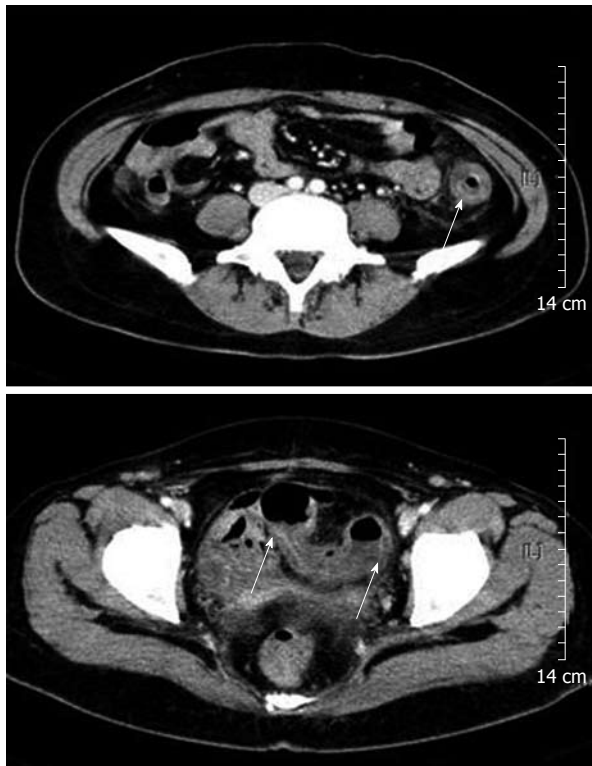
Abdominal computed tomography. A: Circumferentially layered wall thickening and pericolic fat infiltration at the descending colon (arrow); B: Circumferential wall thickening and pericolic fat infiltration at the proximal sigmoid colon (arrows).
